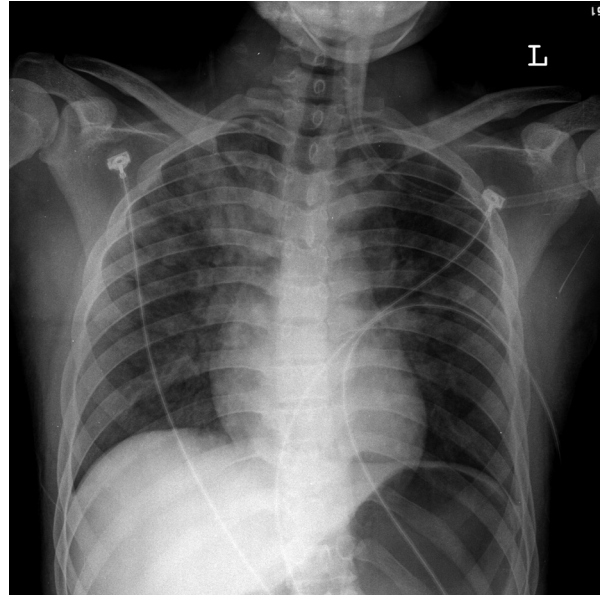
Portable chest radiography showed bilateral peri-hilar infiltrates with right-sided predominance (2 hours post-operation).
